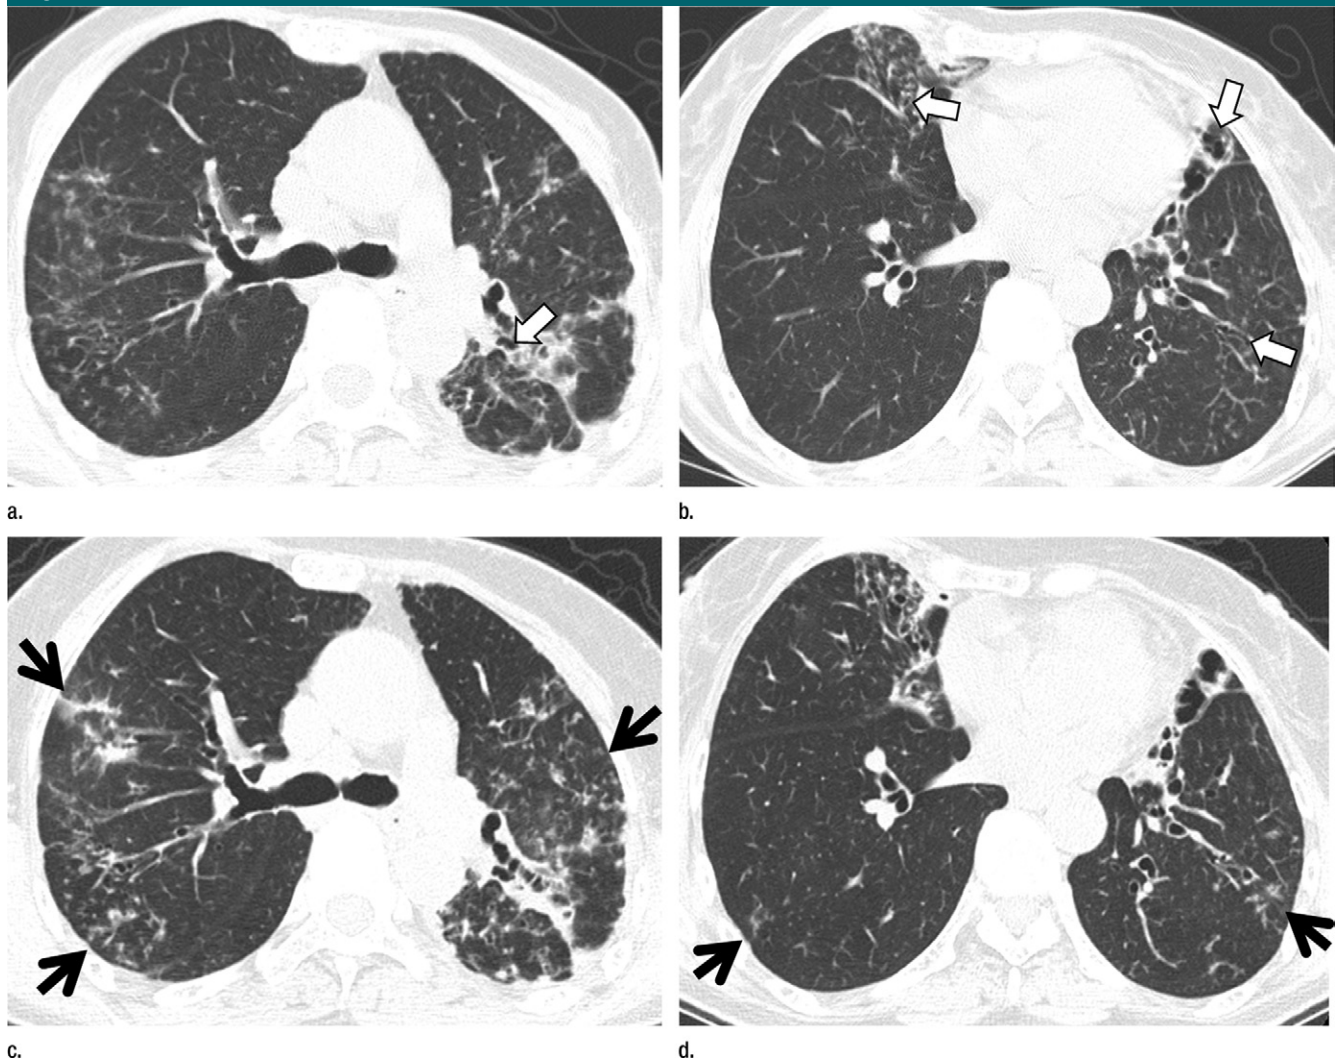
Serial CT scans of *M abscessus* disease of nodular bronchiectatic form in 65-year-old woman. (a, b) Transverse CT scans (2.5-mm-section thickness) obtained at presentation at levels of (a) right upper lobar bronchus and (b) right inferior pulmonary vein show extensive cellular bronchiolitis with tree-in-bud signs in both upper lobes and left lower lobe. Also note bronchiectasis (arrows) in right middle lobe, lingular division of left upper lobe, and left lower lobe. (c, d) CT scans obtained at similar levels to a and b, respectively, 1 year after clarithromycin-containing therapy show rather increased extent of cellular bronchiolitis (arrows) in both lungs.
